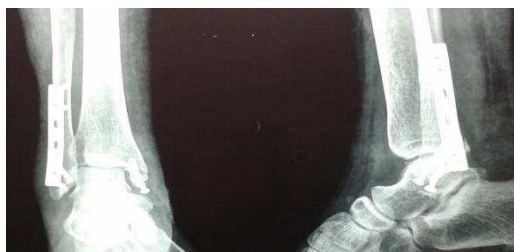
Antero-posterior and lateral view Radiograph pre-op lateral view radiograph post-op
